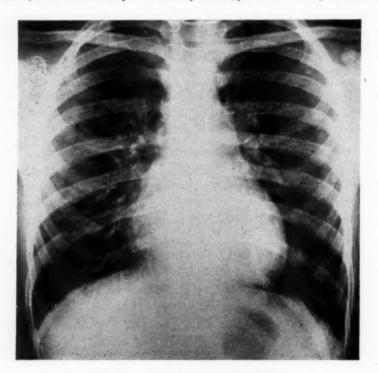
X-ray picture of the chest.
